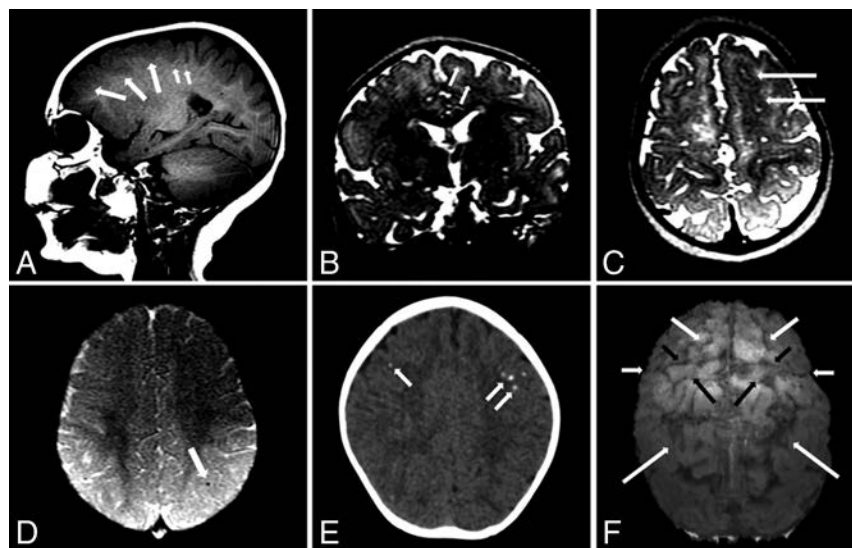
MR imaging and CT of a 10-month-old girl with microcephaly developed postnatally with possible congenital Zika syndrome. Sagittal T1-weighted image shows frontal polymicrogyria (*medium white arrows*) and very subtle hyperintense punctate foci, representing calcifications at the cortico-subcortical white matter junction (*small white arrows*). Coronal and axial T2-weighted images (B and C, respectively) show the thick and irregular cortex at the superior frontal sulcus (*white arrows*). Axial SWI (D) shows a small punctate focus, representing calcification at the cortico-subcortical white matter junction (*white arrow*). Axial CT scan (E) shows punctate foci in both frontal lobes. An echo-spoiled gradient-echo volumetric (3D reconstruction) image (F) shows malformation and prominence of brain high frontoparietal convexity gyri and sulci, predominantly at the left hemisphere: The superior frontal sulcus (*medium white arrows*) is well-identified bilaterally, as well as precentral (*short black arrows*), central (*short white arrows*), and intraparietal (*long white arrows*) sulci. The left hemisphere is more reduced than the right hemisphere; the left precentral gyrus (*large black arrows*) seems to be the most reduced in volume. These findings are located probably where the polymicrogyria is most severe, according to the T2-weighted images (B and C). These findings are better seen in a 3D reconstruction (F) than in sectional images (A–C), despite the presence of movement artifacts in the former.
